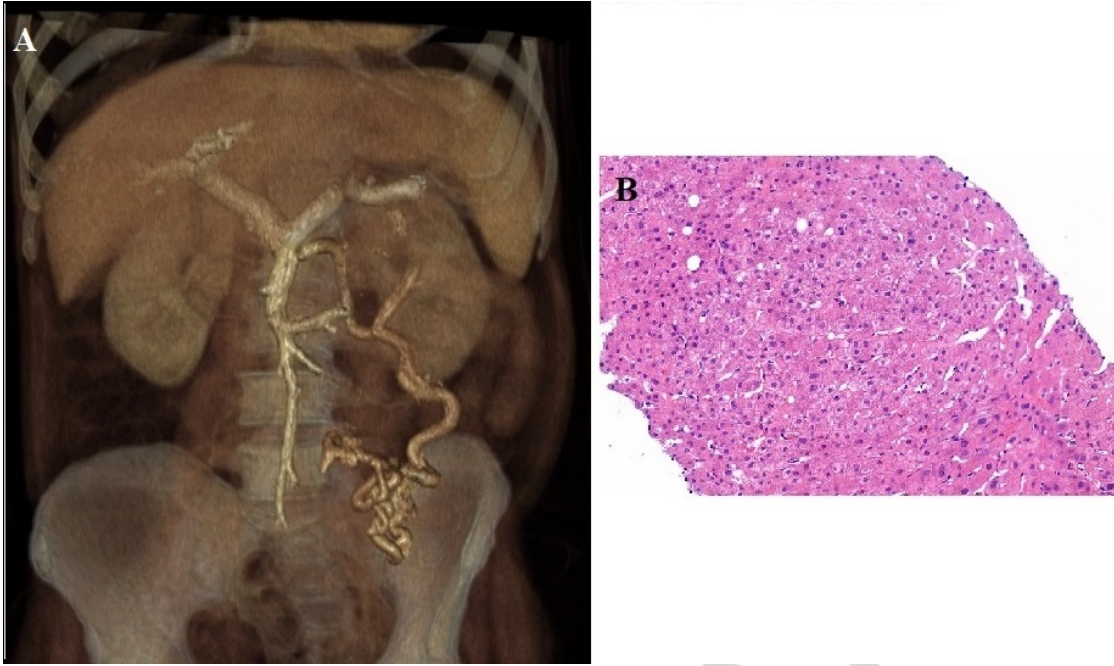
A. CT angiography with 3D reconstruction: peristomal collateral with origin in the inferior mesenteric vein. B. Liver biopsy: sinusoidal dilatation, hepatocyte atrophy, sinusoidal and perivenular fibrosis.
